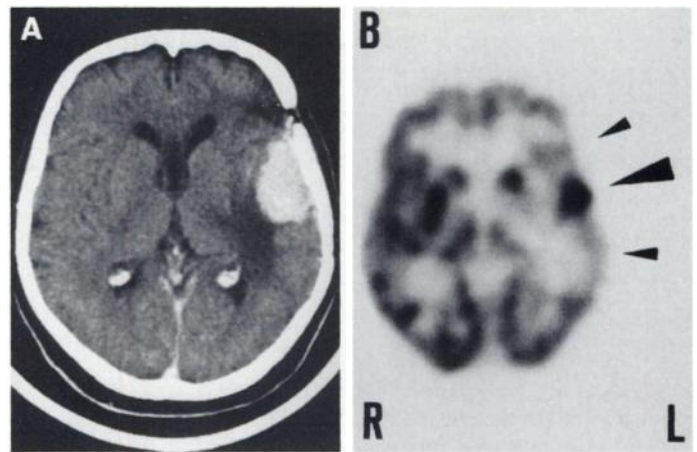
Corresponding contrast-enhanced CT (A) and PET (B) scans of Patient 3 who had tumor recurrence 8 yr after removal of a convexity meningioma. Marked contrast-enhancement and perifocal edema can be seen on the CT scan. PET scan shows intense focal tumoral FDG uptake (SUV = 9.3; TGR = 1.27; large arrowhead) and significantly reduced uptake of peritumoral gray matter (smaller arrowheads). WHO tumor classification: grade 3.
